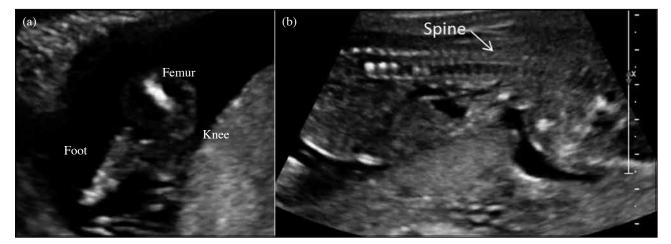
Ultrasonogram at 17 weeks of gestation in the second pregnancy in 2011. (a) The femur is grossly shortened with underdevelopment of the tibia and fibula. (b) Poor mineralisation of the vertebral column is shown
